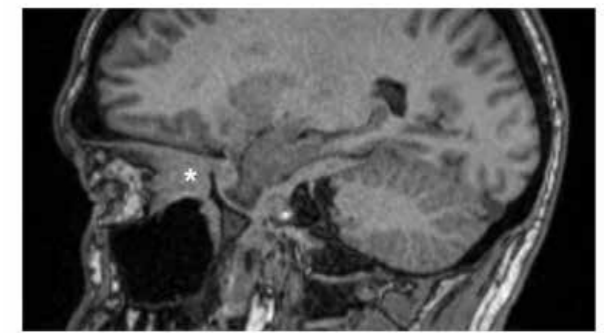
Sagittal T1-weighted MRI showing posterior extent of the right orbital mass lesion (asterisk).
